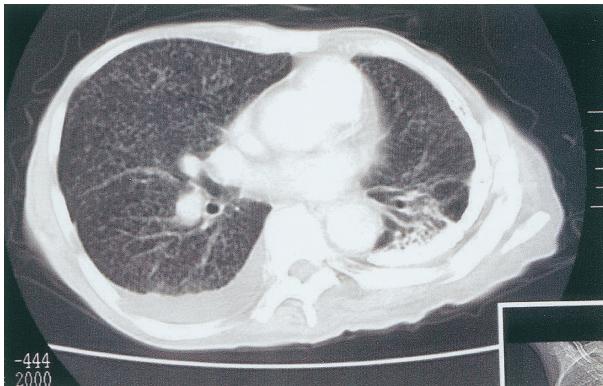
Chest CT in August 2004, showing a diffuse miliary nodular shadow.
